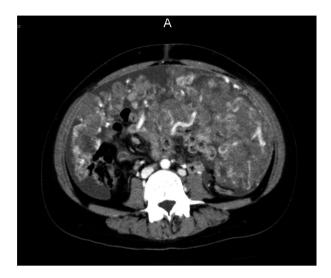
Computed tomography shows a large heterogeneously enhancing mass invading the abdominal cavity.
